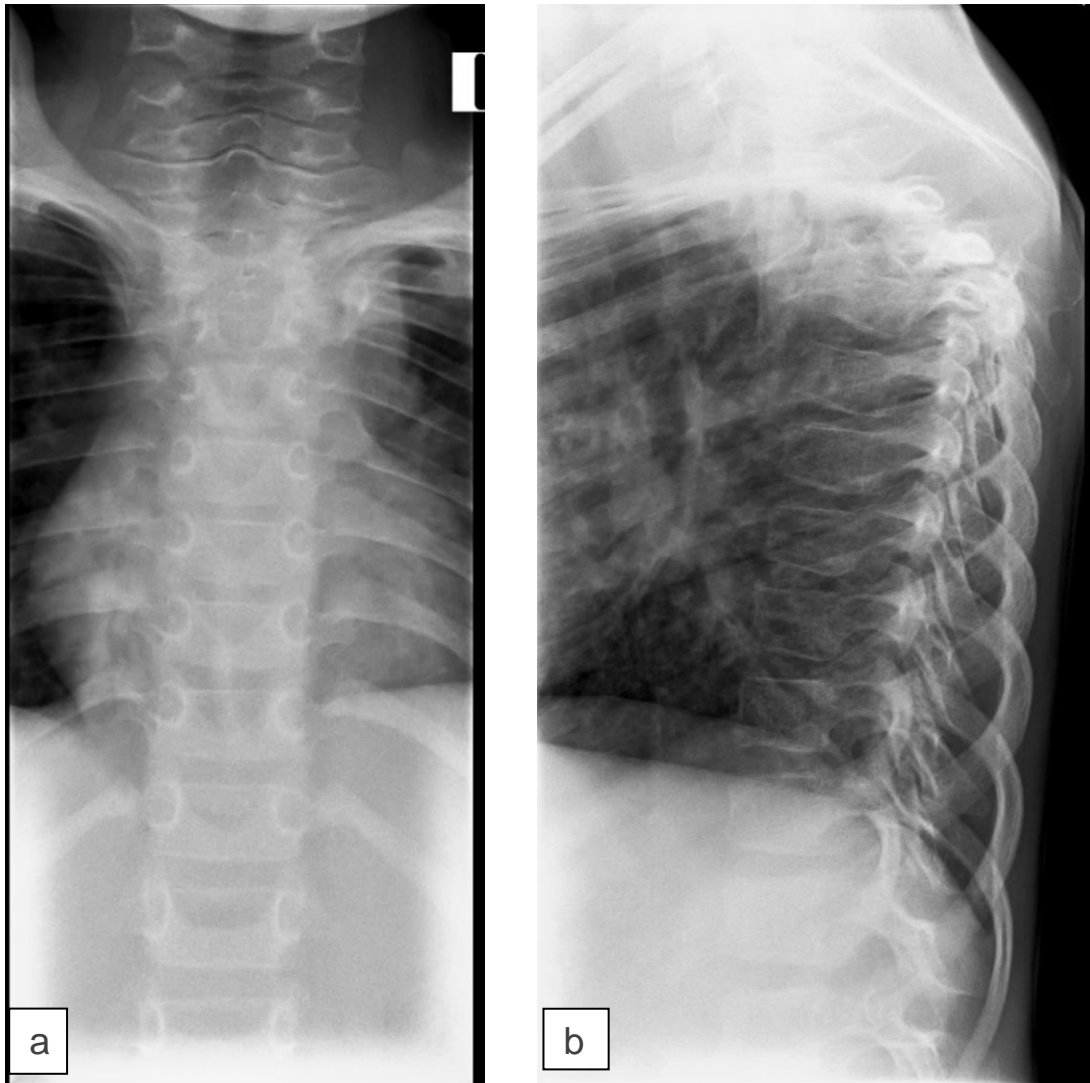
Thoracolumbar spine X-rays (AP and lateral views) of the child above: TB spine involving T3, T4, T5 and T6 with vertebral body destruction and gibbus formation. Paraspinal mass demonstrated on the lateral.
